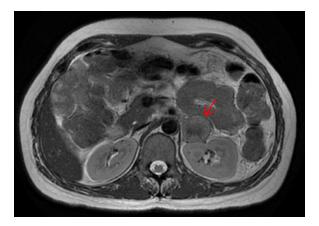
MRI cross section of left adrenal gland.
